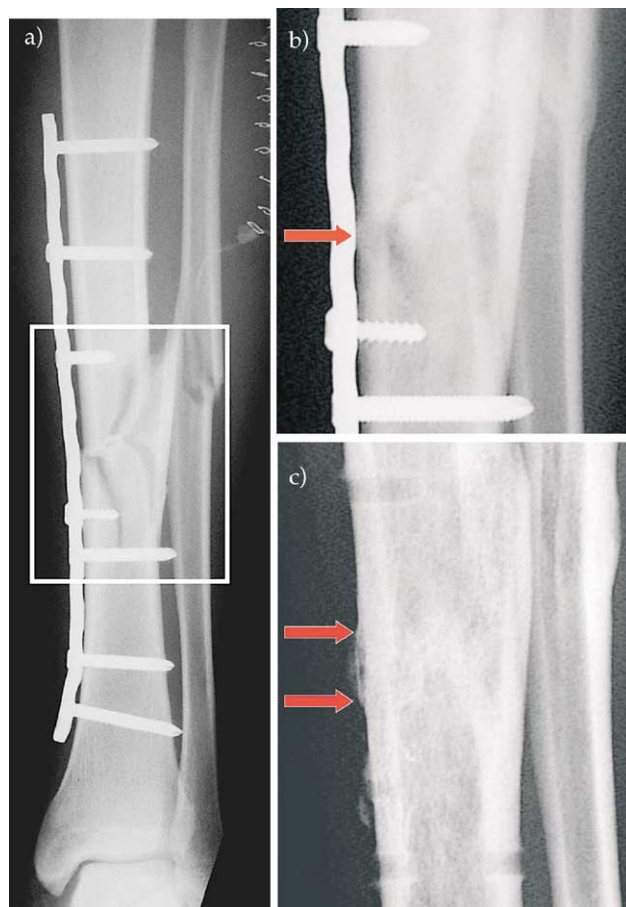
Callus healing underneath the internal fixator. Clinical case of a lower leg fracture in a 19 years old patient treated with a 4.5/5.0 mm LCP. The postoperative anteroposterior radiograph shows the no contact situation between plate and bone (a). The enlargement of the area at the fracture site shows callus formation underneath the plate at 4 months (b) and after implant removal at 2 years (c) proving vital bone and periosteum underneath the implant.
